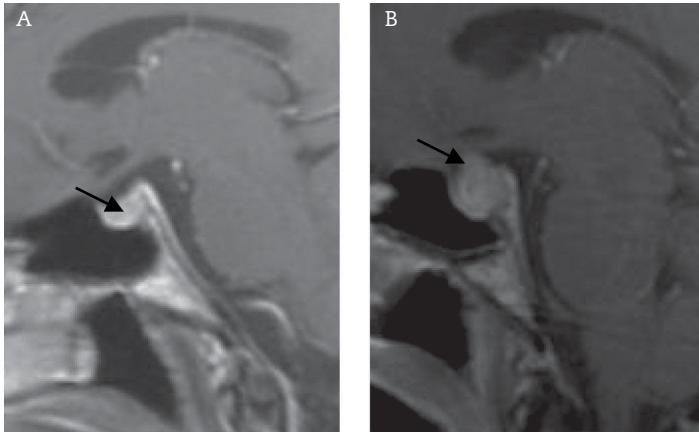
MRI of brain before initiation of ipilimumab (A) and three months posttherapy (B).
